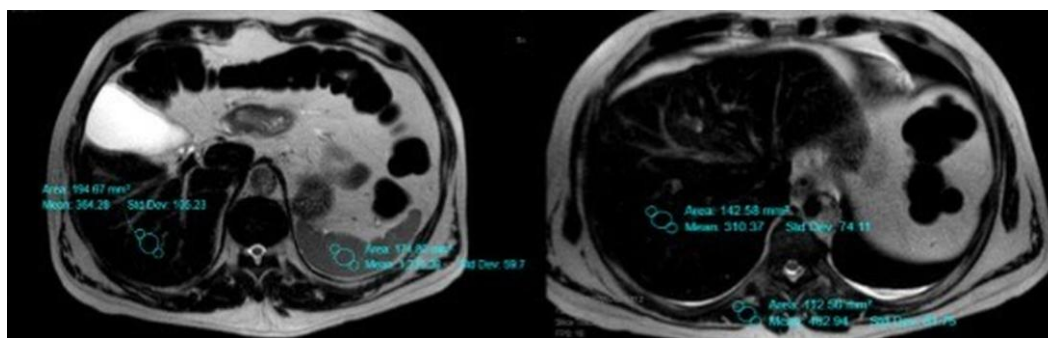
T2-weighted imaging (T2WI) reveals a hypointense signal in the liver parenchyma, indicative of iron deposition
